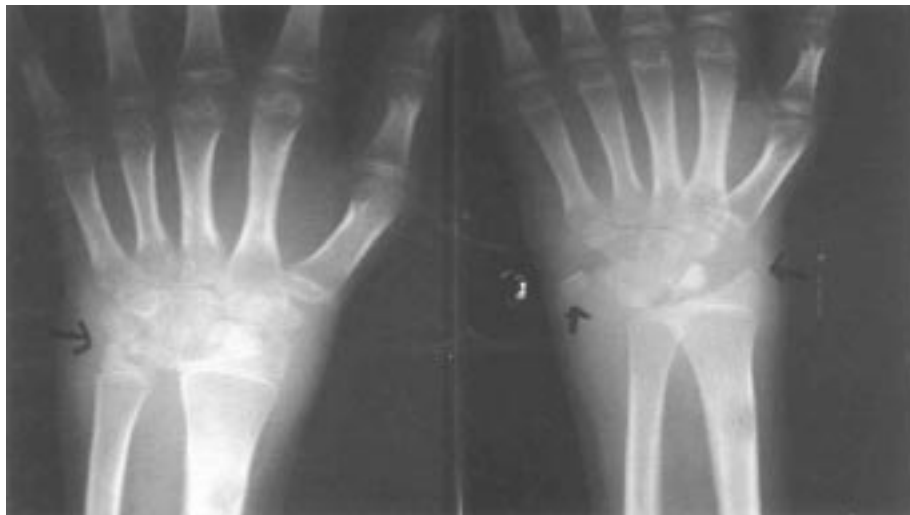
Initial radiographs showing scapholunate dissociation
